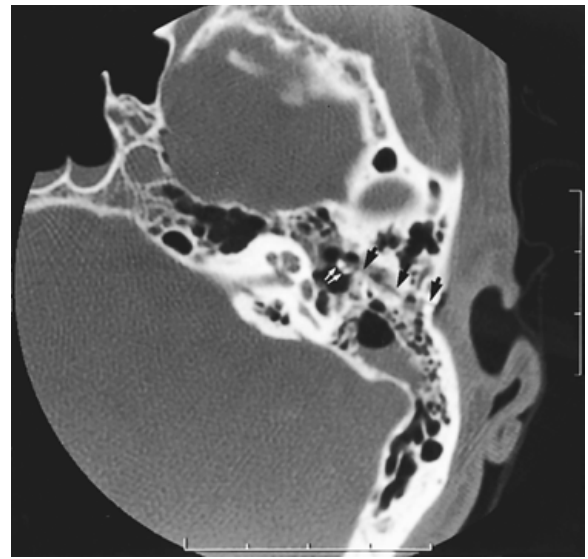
Longitudinal temporal bone fracture, axial computed tomography. A fracture line traverses the temporal bone, running parallel to the long axis of the bone (black arrows). The facial nerve was uninvolved, but the malleoincudal articulation was dislocated (not shown). However, note the abnormal configuration of the ossicular chain in the mesotympanum (white arrows).
